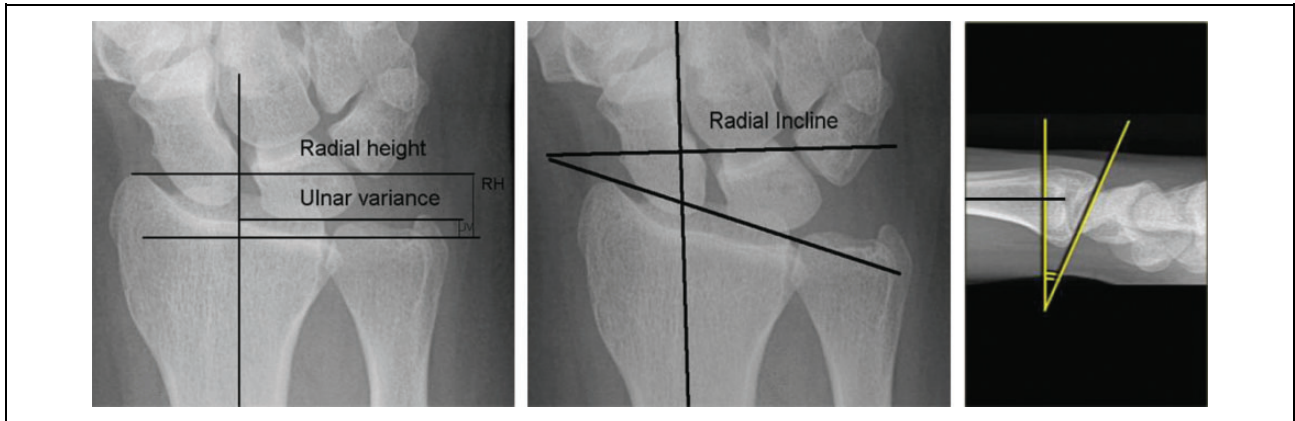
Standard radiographs, posteroanterior and lateral views were taken for both wrists. All radiographs were digitized and imported into a software program (AutoCAD 2000). The following distal radius radiological indices were measured three times: radial height, radial inclination, ulnar variance, and palmar tilt. The results of the three measures were averaged for analysis.
